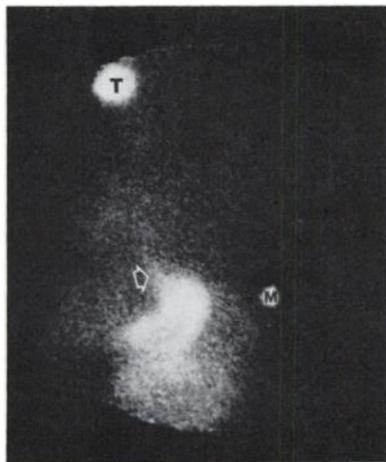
Barrett's esophagus (arrow) visualizing on pertechnetate scintigram. T = thyroid gland; M = marker at level of xiphoid.
